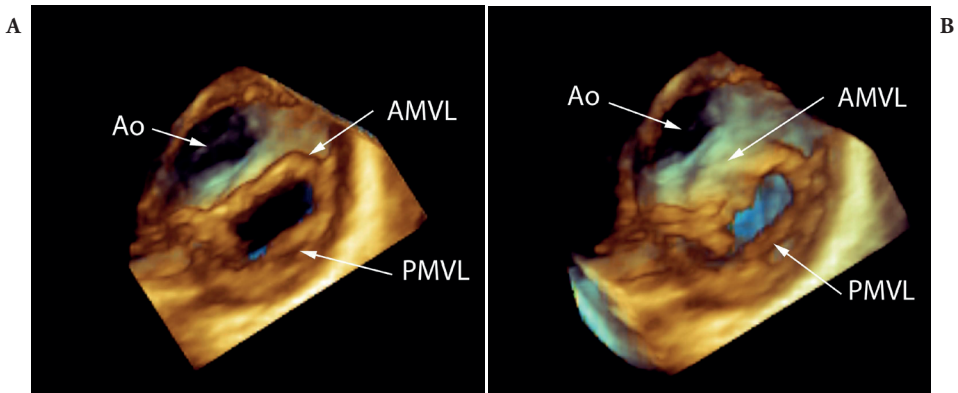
Rendered views of the mitral valve by transthoracic 3DE. (A) This is a projection of a normal mitral valve viewed from the ventricular aspect. The mitral valve is viewed directly en face so that the leading edge of the anterior and posterior leaflets can be visualised along with the aorta in the far-field. (B) This is a similar projection of the mitral valve to that shown in (A). However, the rendered image has been angulated slightly so that the depth of the anterior leaflet of the mitral valve can be visualised. This assists in imaging of abnormalities in this region such as true clefts of the mitral valve or the bridging leaflets in atrioventricular septal defects. Ao, aorta; AMVL, anterior mitral valve leaflet; PMVL, posterior mitral valve leaflet.
